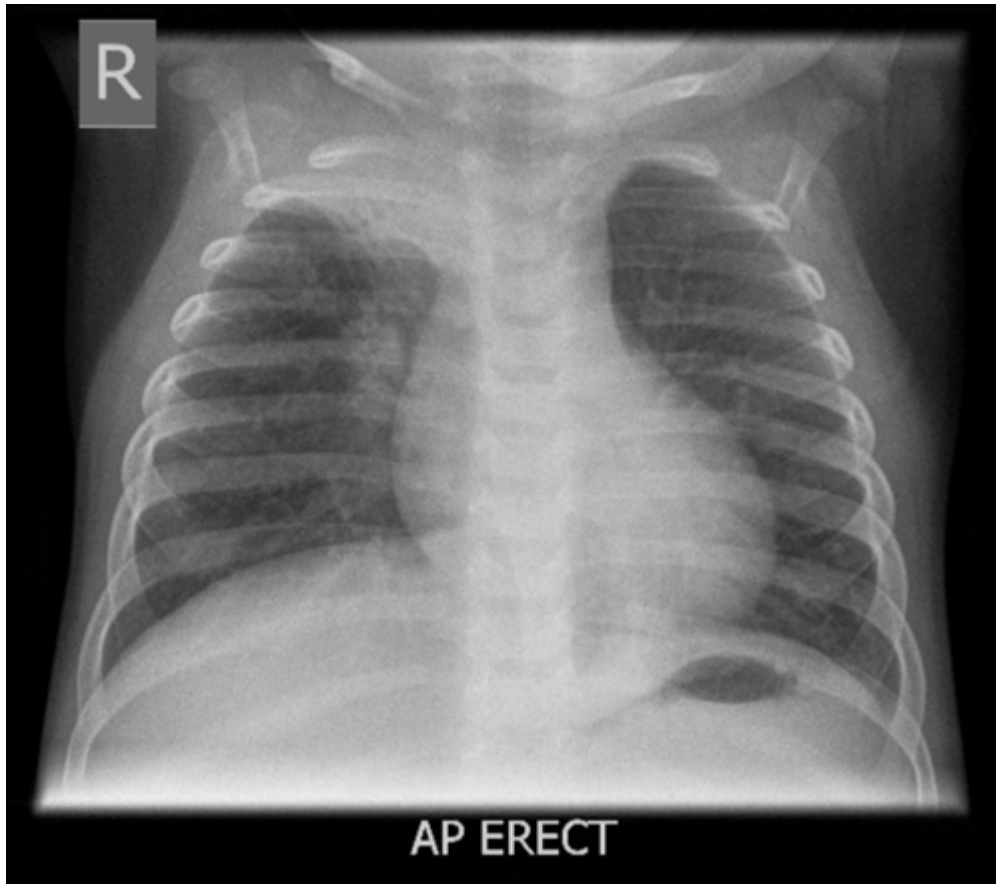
Repeat X-ray demonstrates worsening collapse and consolidation within the right lung apex. There is a further area of air space opacification within the right lower zone and the left retrocardiac region. ↩
